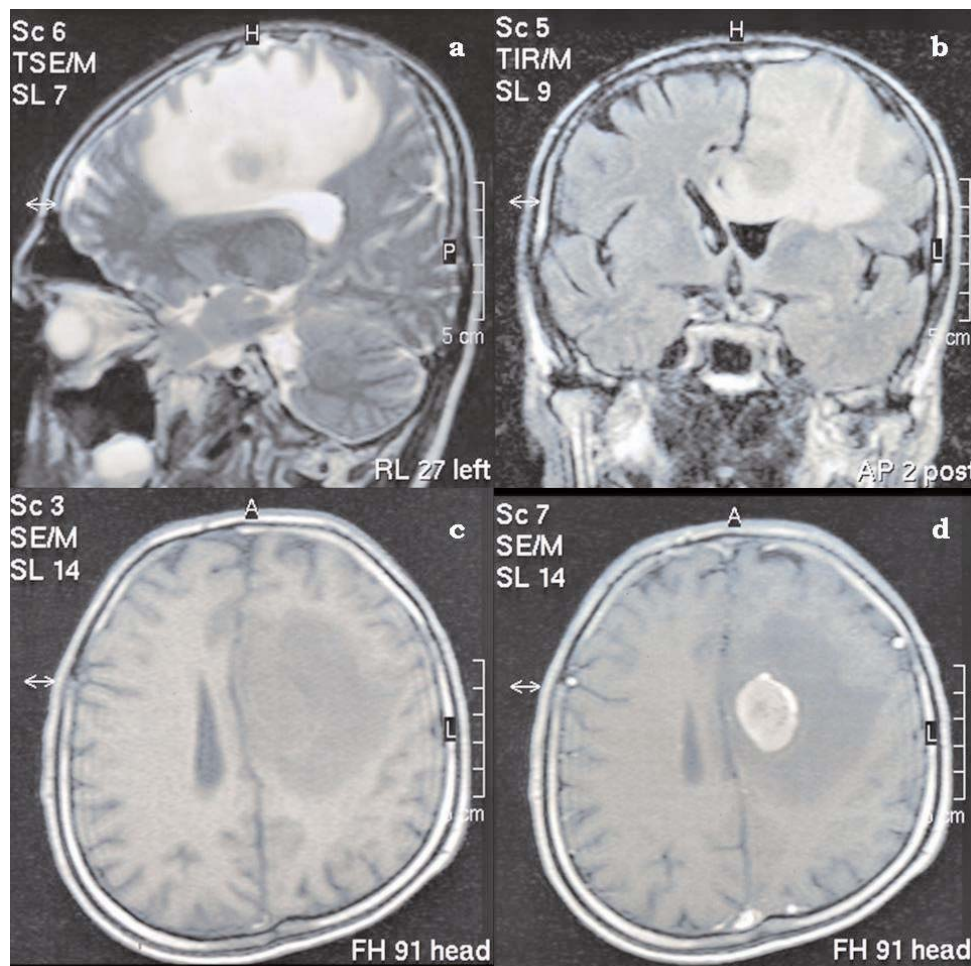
On magnetic resonance imaging, a left-sided mass lesion at low signal intensity was observed that involved the surface of the parasagittal aspect of the left frontal lobe of the brain and that abutted the meninges (a). The mass lesion appeared to compress the frontal horn of the left lateral ventricle and to traverse the corpus callosum (b) and was associated with the necrotic foci and the intense edema leading to left-sided shift of the midline structures (c). Following the administration of the contrast medium, the mass lesion demonstrated notable circumferential enhancement (d).
